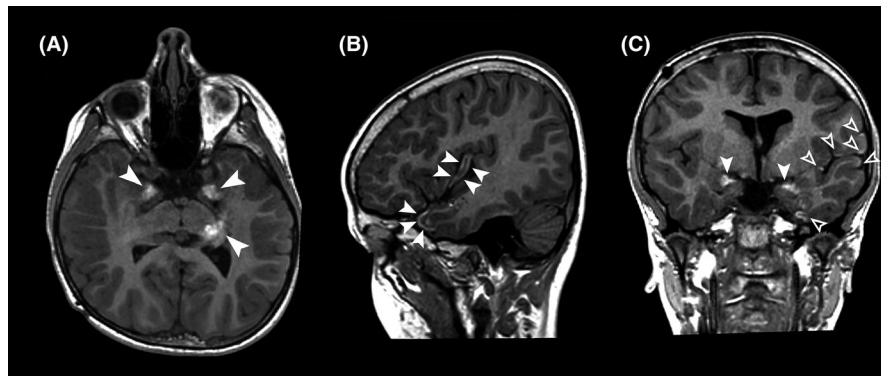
MR TFE-3D T1-weighted images of our 6-year-old patient with Neurocutaneous Melanosis. Axial (A), sagittal (B), and coronal (C) planes of T1-weighted images show a 6-year-old girl patient with melanin intraparenchymal and leptomeningeal accumulation. White arrowheads show melanin hyperintensity in the amygdala bilaterally, in the thalamic and retro-thalamic cistern. In (B) leptomeningeal hyperintensity as manifestation of leptomeningeal melanosis in the left temporal lobe is well depicted (empty arrowheads)
